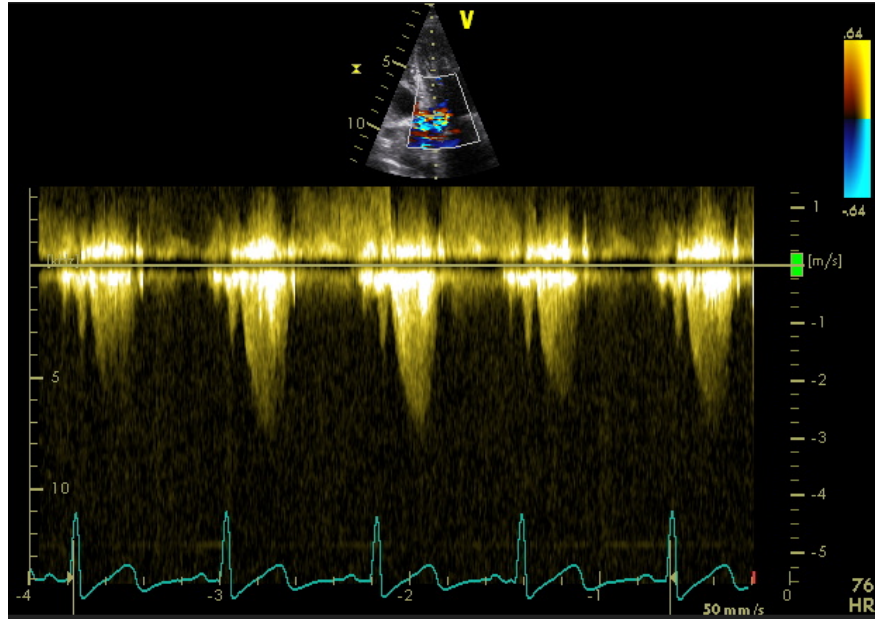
Continuous Doppler through the left ventricular outflow tract: end -systolic gradient of 64 mmHg.
